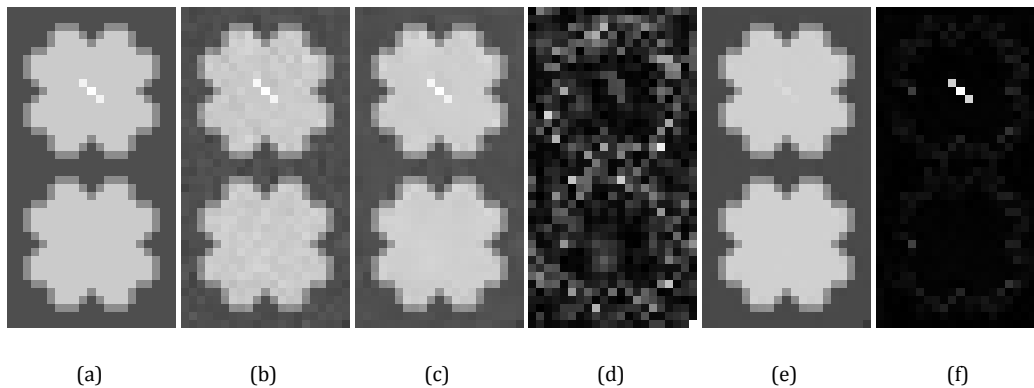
The disadvantage of the ‘non-local’ property of NLM in DCE MRI
